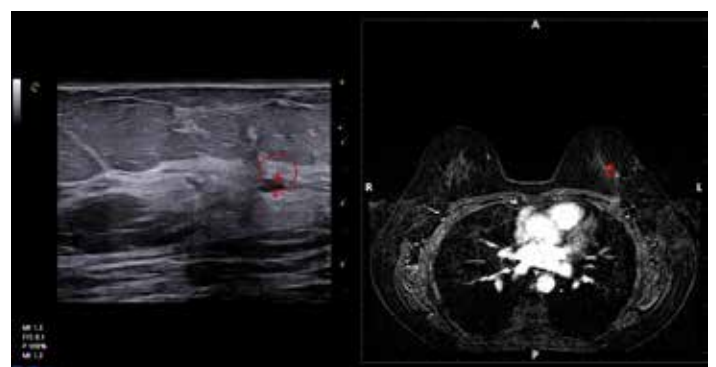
MRI-US Navigation phase: minimum disalignment between the target and the lesion (QSE SX) in a fatty small breast
